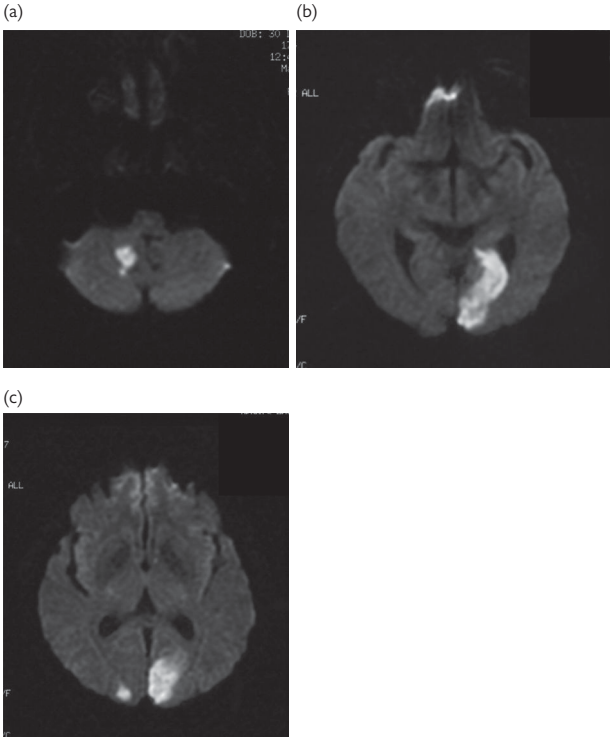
Diffusion-weighted MRI showing multiple infarcts in the PCA territory involving the (a) right cerebellum; (b) left cortical PCA territory; and (c) both occipital poles. © Hugh Markus.
